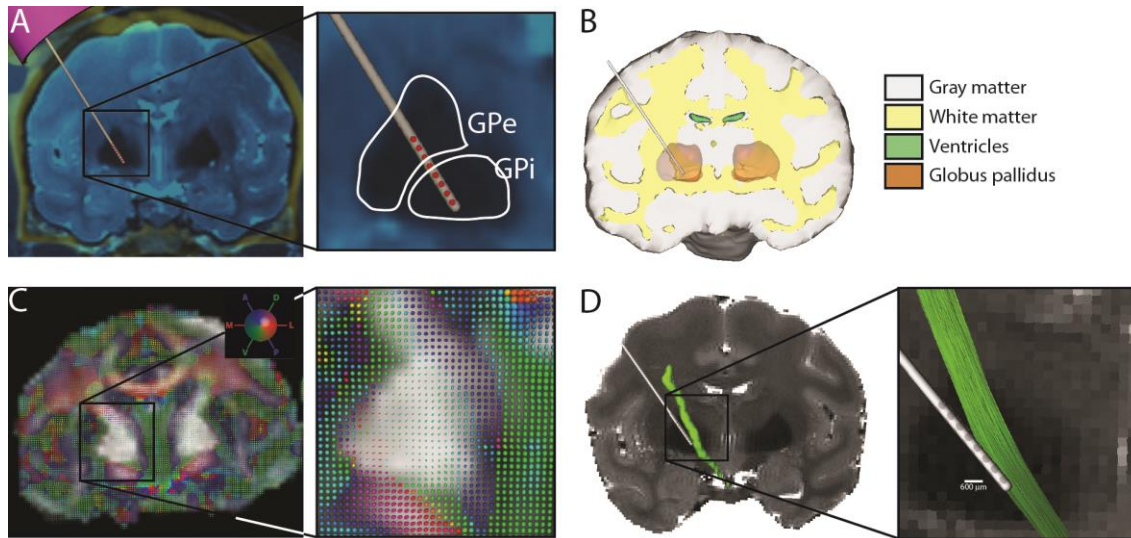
Brain tissues were segmented manually and multi-compartment axon tracts were created using probabilistic tractography. Preoperative MRI was co-registered with postoperative CT (A). Gray matter, white matter, and the lateral ventricles were segmented using the co-registered MRI, and a digital representation of the DBS lead was placed in accordance with the co-registered postoperative CT imaging (B). Probabilistic tractography was performed using DWI (C) to segment the  $CST_{arm}$  within the right hemisphere (D). The segmented region of the internal capsule was used to guide the pseudorandom creation of 1000 multi-compartment axon geometries.
